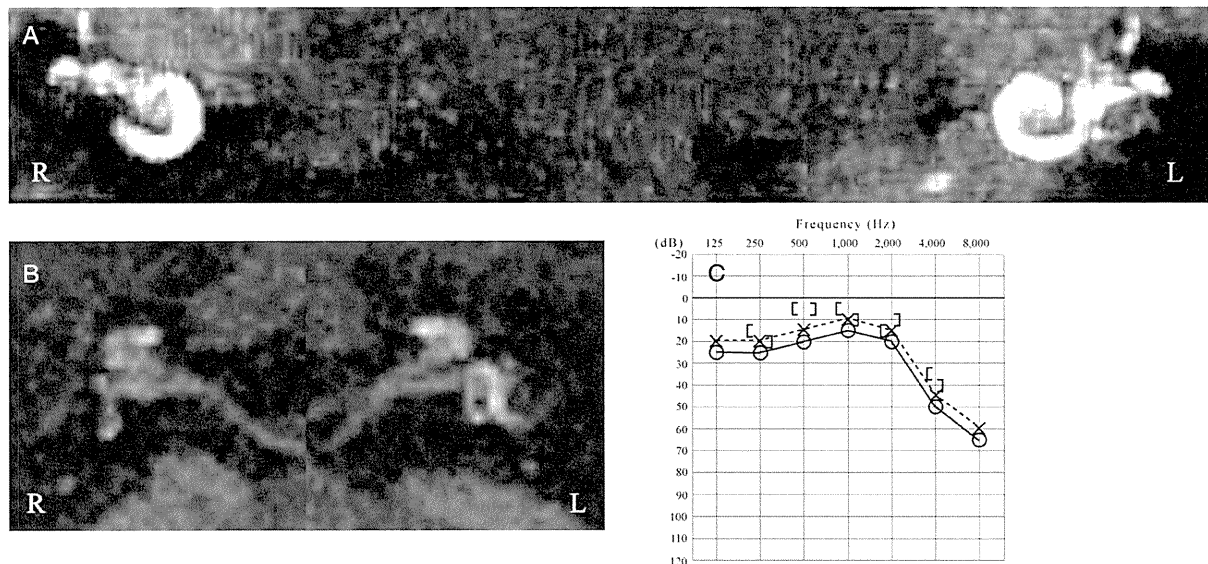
MRI imaging after therapy. (A, B) The area representing the perilymphatic space enhanced by gadodiamide is increased. (C) Hearing is recovered.
